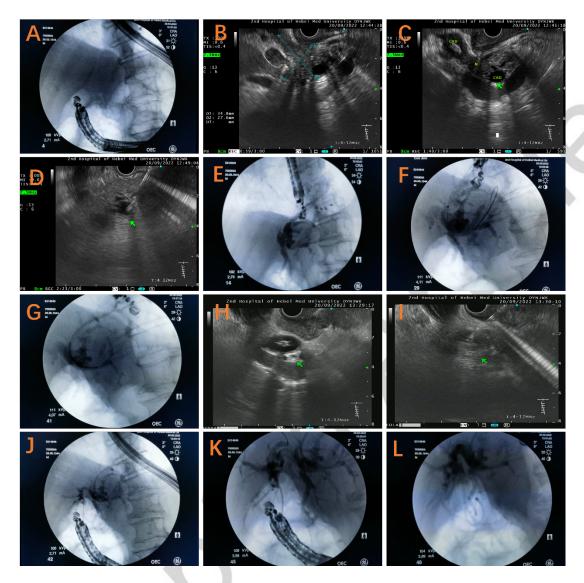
A: It was difficult for endoscopic ultrasound to enter the duodenum, so ultrasound scan was performed in the stomach. B: Endoscopic ultrasonography showed mass in the common bile duct; C: dilated bile duct; D: Puncture the dilated bile duct; E-G: left hepatic bile duct development was observed, and the guide wire was difficult to enter the common bile duct, and the stent was inserted. H-I: punctured dilated bile duct; J-L: Intrahepatic and extrahepatic bile duct was developed, the lower common bile duct was not developed, and stent was inserted.
